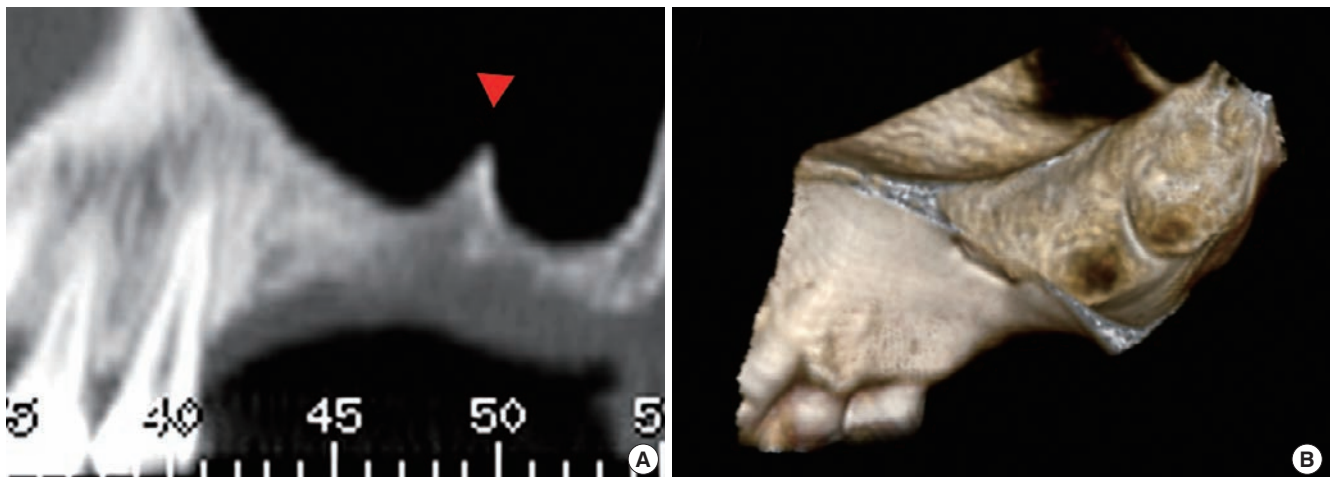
Pre-operative computed tomography. (A) Panoramic view. (B) Three-dimensional reconstructed image. Note that there was a septum at the second molar area in the left maxillary sinus.
